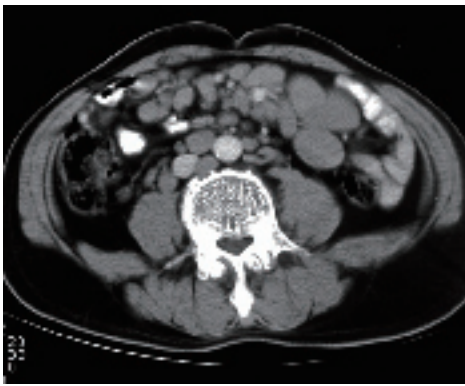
Diff-use type: Enhanced CT showing diffuse, clear margins, homogeneous density enlarged lymph nodes in the mesenteric and retroperitoneal region.
